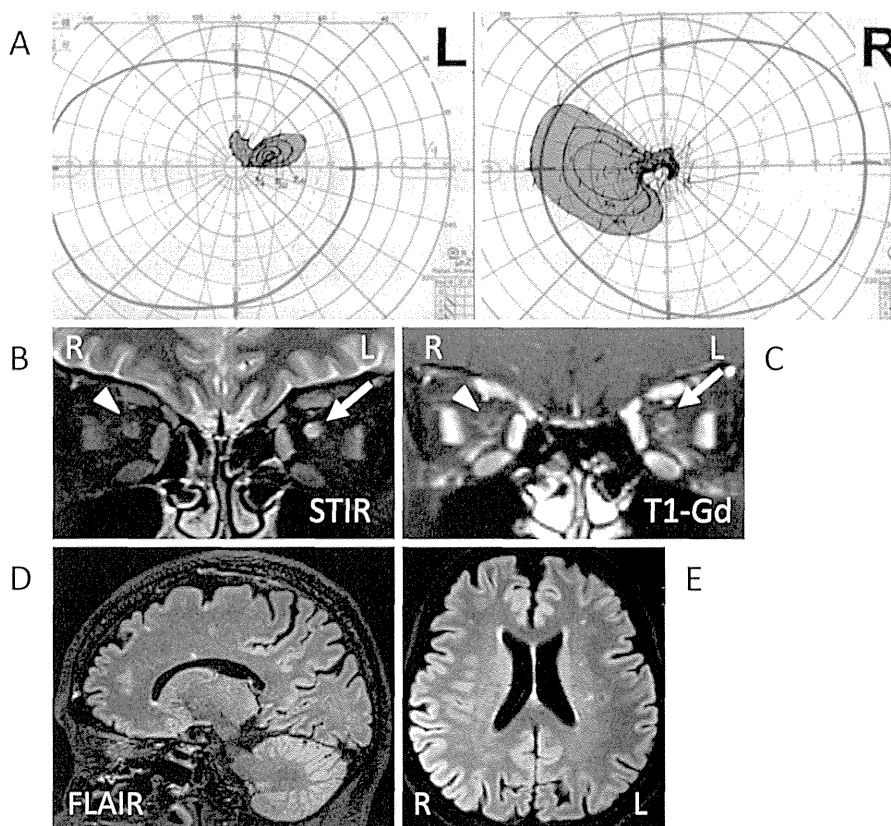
The visual impairment and the magnetic resonance images of the present case. The Goldmann visual fields on admission are highlighted (A). The left optic nerve showed high signal intensity on the STIR coronal image (white arrow, B) with marginal contrast enhancement (white arrow, C). The right optic nerve showed no remarkable findings (arrow head, B and C). The brain showed no particular findings except for the optic nerve on FLAIR sagittal (D) and axial (E) images. FLAIR: fluid-attenuated inversion recovery, STIR: short inversion time inversion-recovery, T1-Gd: gadolinium enhanced T1
